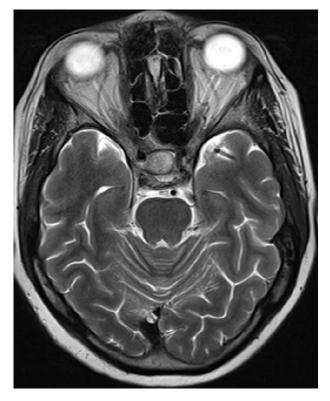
T2-weighted magnetic resonance imaging scan of the brain in a sagittal section, showing a well-defined heterogeneously enhancing mass lesion (measuring $15 \times 13 \times 11$ mm) in the sella with mild suprasellar extension. The sella is widened.
